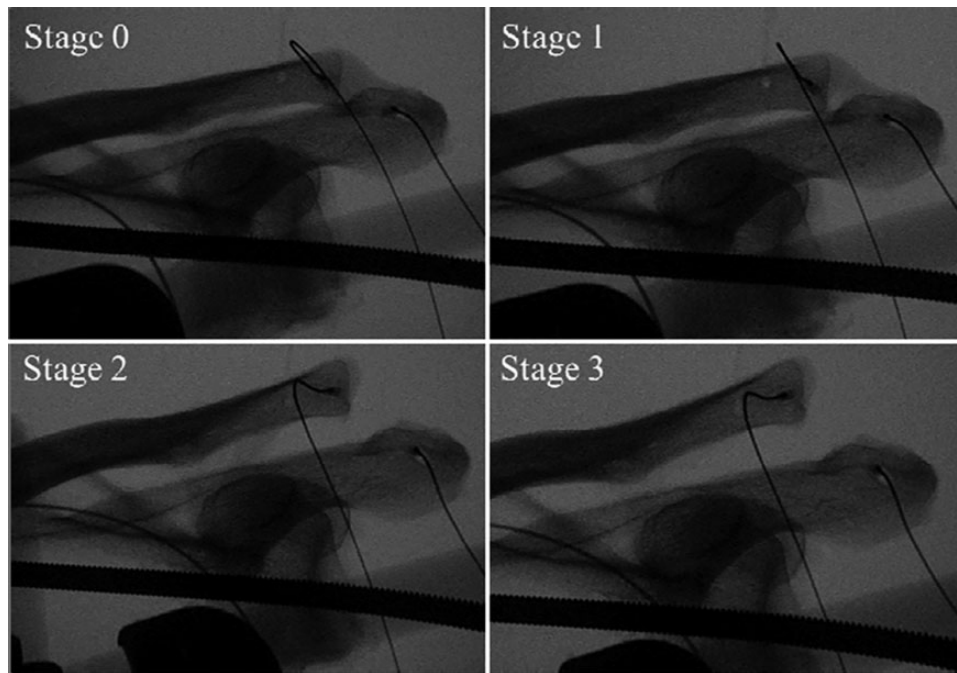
Zanca view radiographs for each sectioning stage.
